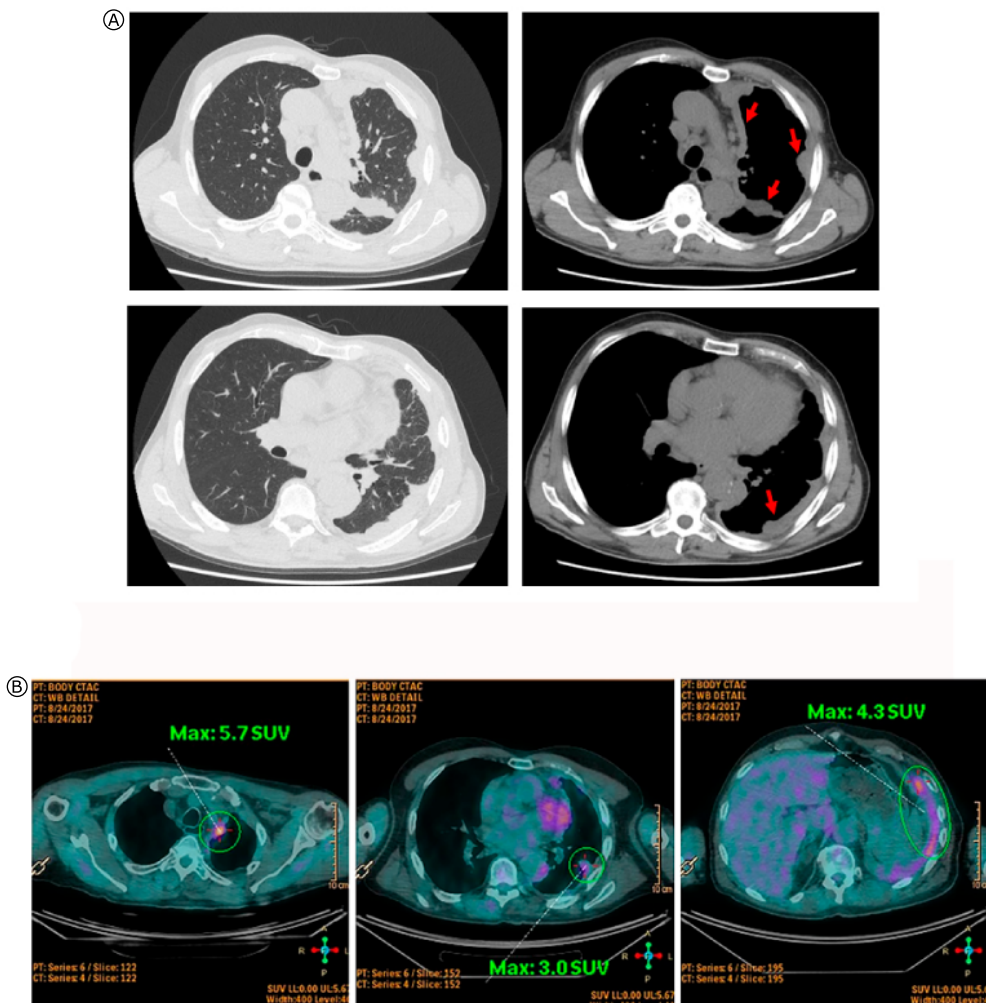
Representative images of the thorax from a male patient diagnosed with biphasic pleural malignant mesothelioma. (A) CT scan showing multiples areas on pleural thickening in the fissure, as well as in mediastinal and parietal pleura, sometimes forming pleural nodules, can be seen in the left hemithorax (red small arrows); (B) 18-FDG PET-CT scan showing various areas of hypermetabolic (glucose avid) tissue in the pleura can be observed on the left hemithorax.
